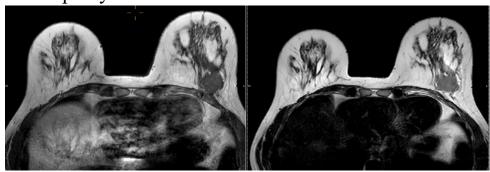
Breast ductal carcinoma on MRI with hyposignal in T1 and T2 sequences
